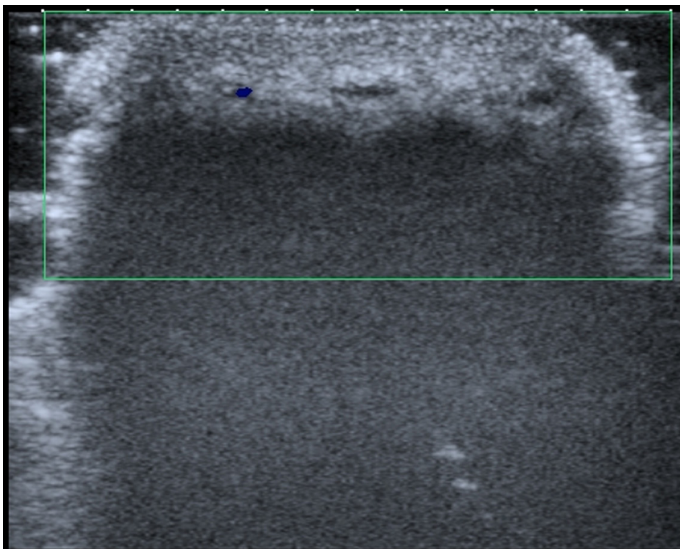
Gray-scale image confirms that the middle penile segment of the superficial dorsal penile vein was compressible with compression maneuver using the ultrasound probe.
